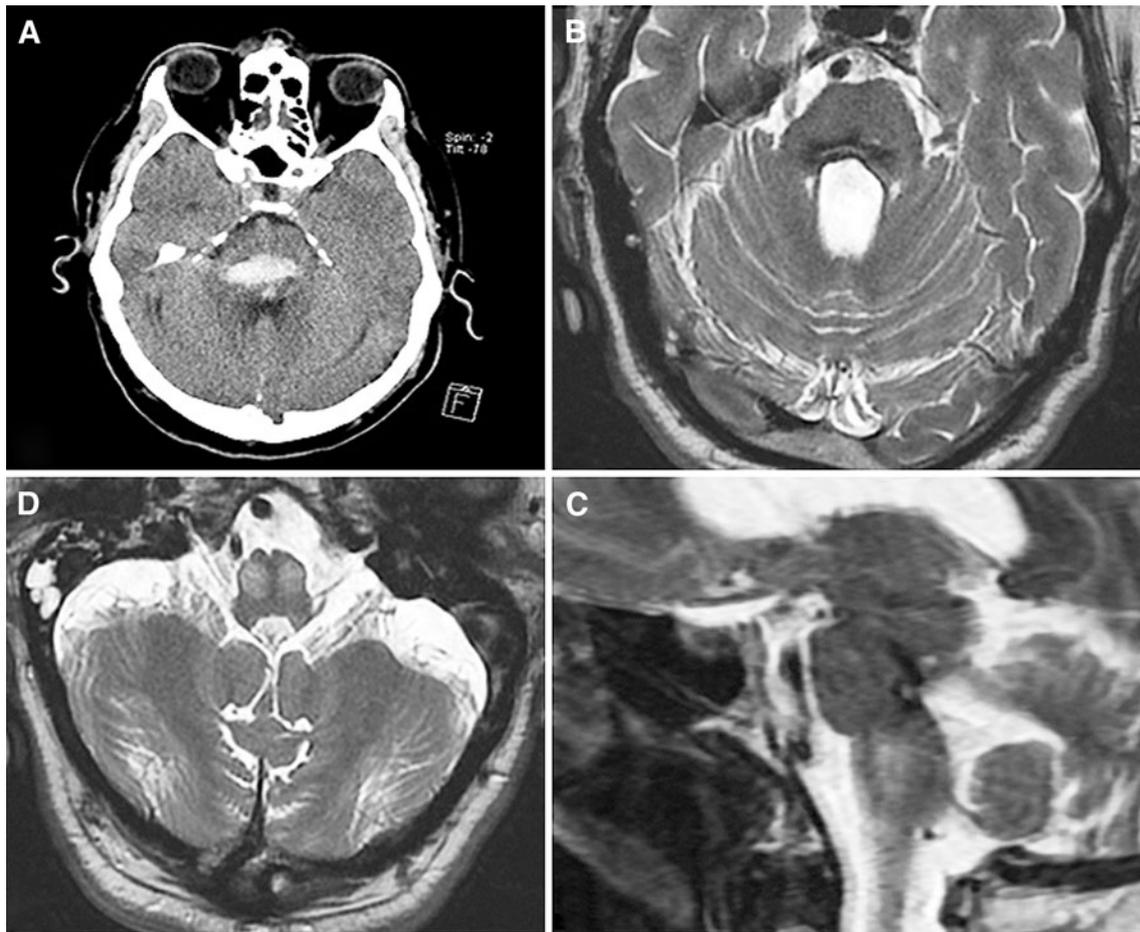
a Brain-CT: the pontine hemorrhage at the onset. b T2-MRI: hemosiderin deposits in the pontine tegmentum 3 months after the onset. c T2-MRI: residual hemorrhage in the pons and olivary hyperintensities in the bulb. d T2MRI: inferior olivary hyperintensities (HIOND)
